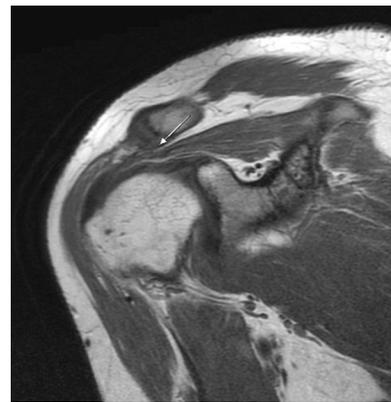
The MRI of right shoulder (T1).
